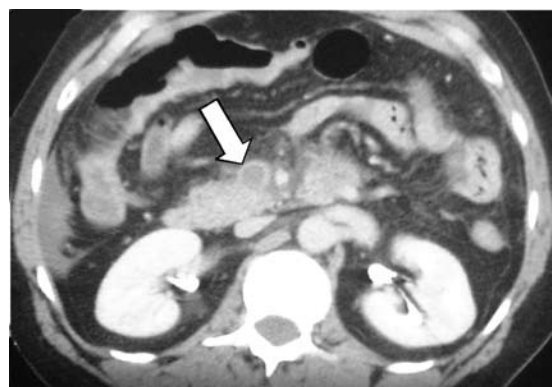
CT angiogram shows superior mesenteric vein thrombosis (arrow) in a 50-year-old man.
